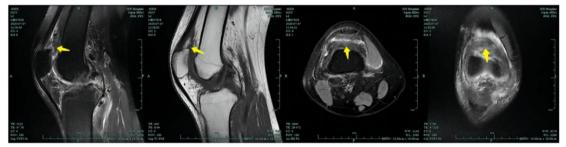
Postoperative MRI of right knee with DPVNS of the knee Postoperative changes that the knee joint space was slightly narrowed and the synovial membrane was thickened. Yellow tines indicate lesions.
